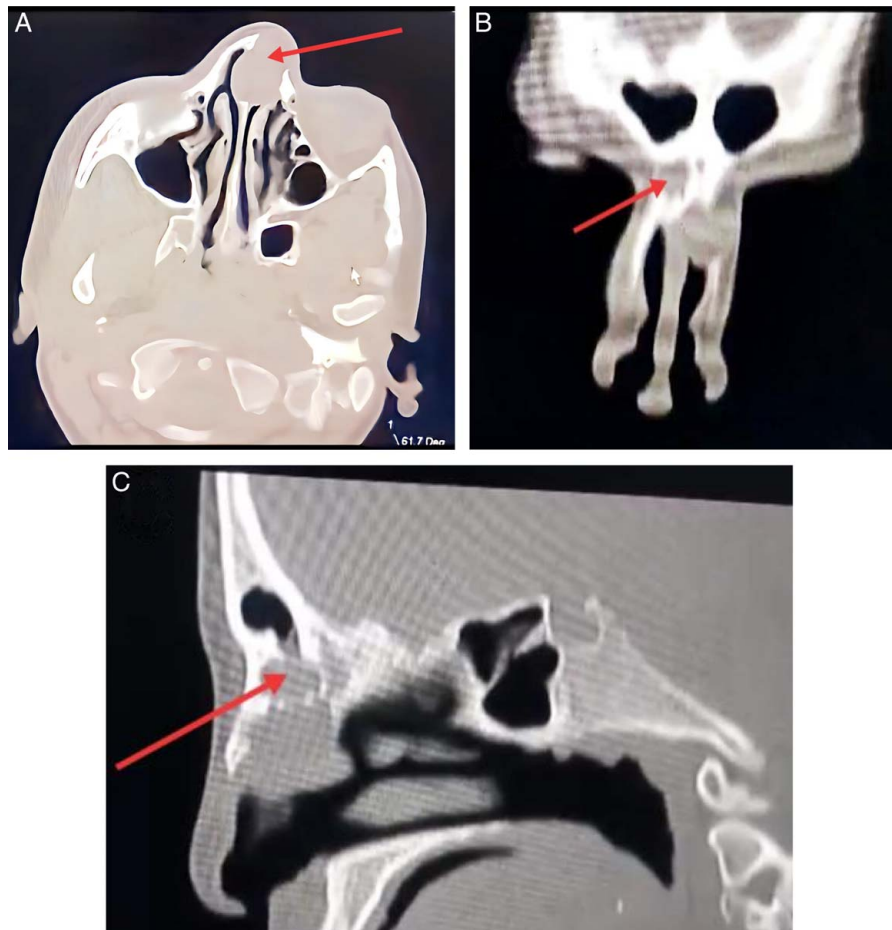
Preoperative computed tomography (CT) scan. (A) Axial CT scan shows a midline mass. (B) Coronal CT reveals bony destruction of the left lateral nasal wall. (C) The sagittal view shows a mass extending to the left frontal sinus with no evidence of intracranial extension.
